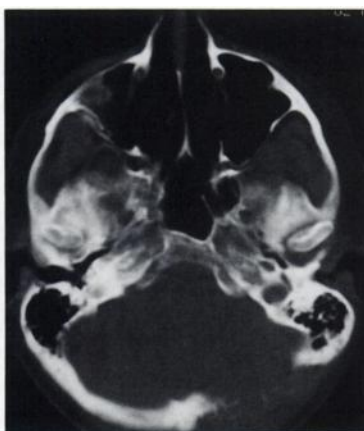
Brain CT scan of depicts a large lytic lesion in the skull.
